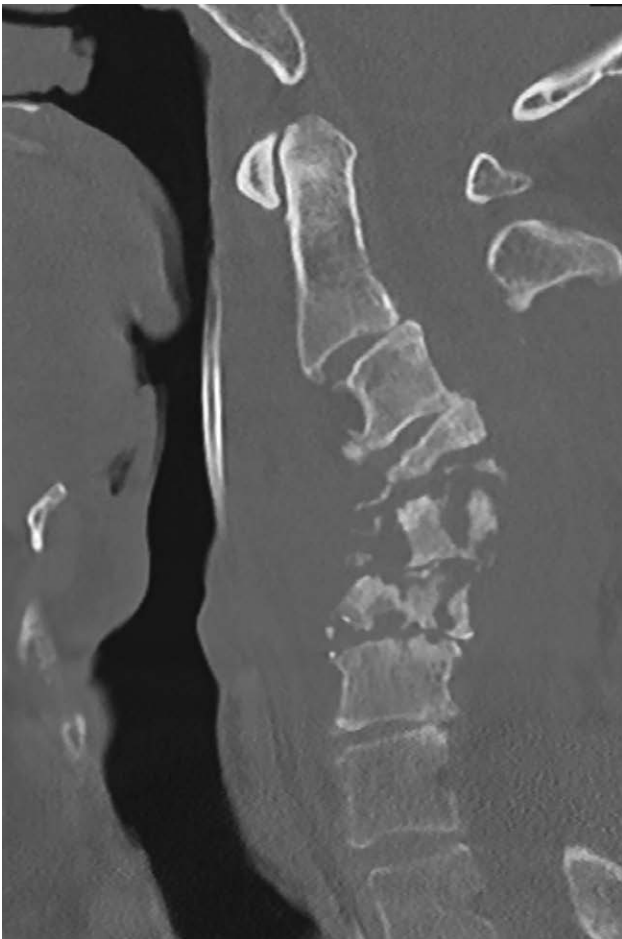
The CT scan image taken the preoperative day shows collapse of infected vertebrae bodies of C3, C4, and C5, causing a kyphotic deformity leading to progressive myelopathy and pain.
